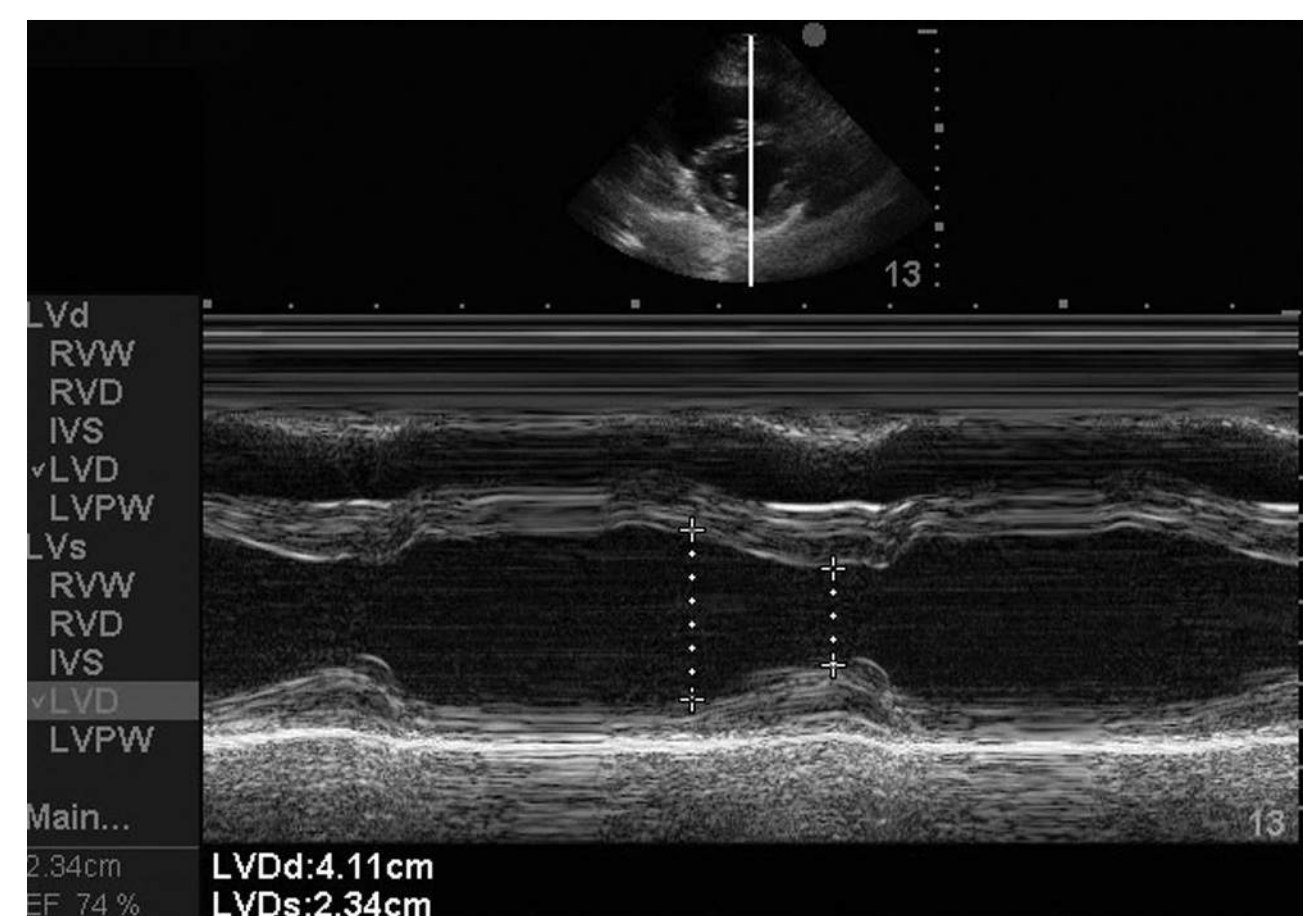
Parasternal short-axis M-mode view, normal ejection fraction (EF). Parasternal short-axis M-mode view at the level of the papillary muscles with M-mode with marker bisecting the left ventricle (LV). Using the LV end-diastolic (LVDd) and end-systolic diameters (LVDs), both fractional shortening and EF can be calculated.
